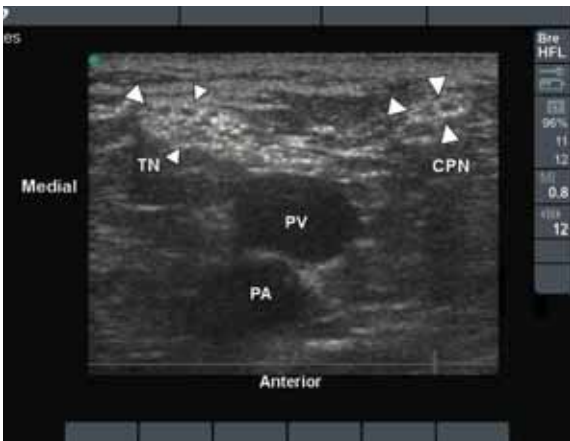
Ultrasound image of the popliteal fossa.
